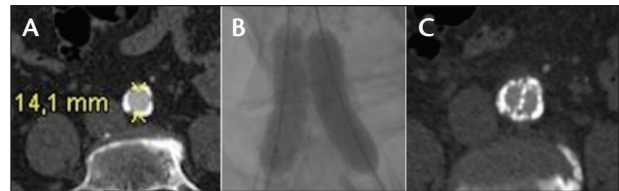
Stenting of both endograft limbs with the kissing-balloon technique in a napkin-ring aorta with a distal diameter of 14 mm. The preoperative diameter of the narrow distal aorta on CTA (A). Stent implantation with the kissing-balloon technique and paving-and-cracking method (B). CTA at 2 years showing the performance of both limbs in the narrow segment of the distal aorta (C).
